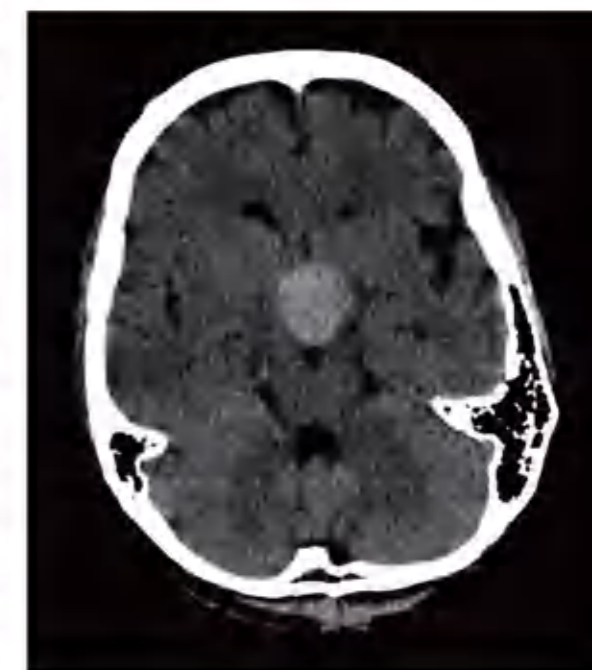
Head computed tomography of a patient with pituitary apoplexy. The hyperdense region represents hemorrhage within a pre-existing pituitary adenoma.
